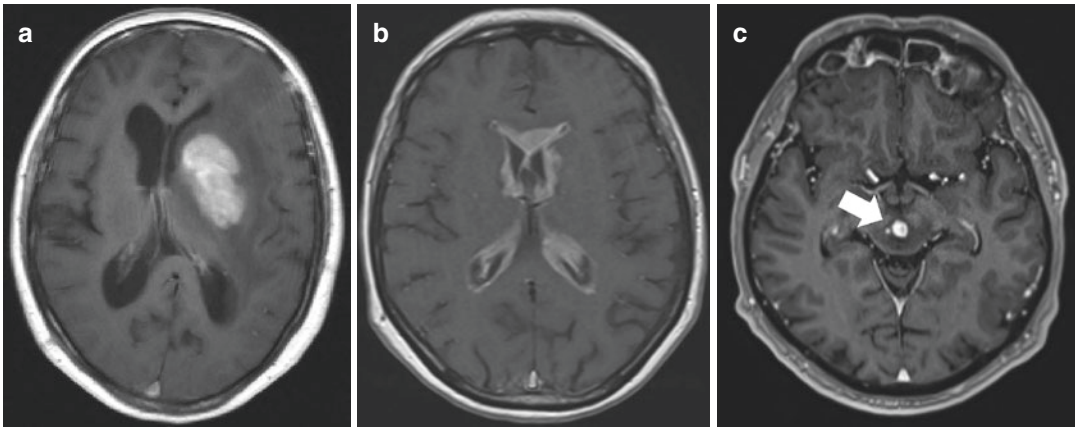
Primary CNS lymphoma on contrast-enhanced MRI: (a) typical appearance in an immunocompetent patient, (b) patient with meningeal involvement, (c) patient with renal transplant and chronic immunosuppression
